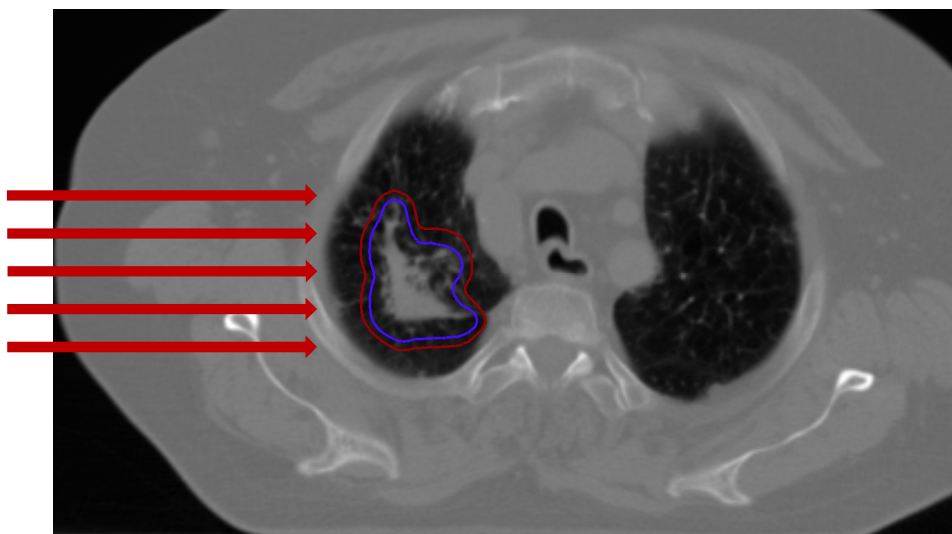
One slice of the patient CT with the original (inner blue contour) and a 4 mm extended PTV, used for the development of the modulator (outer red contour). Figure taken from (Simeonov *et al* 2022) – Figure 1.
